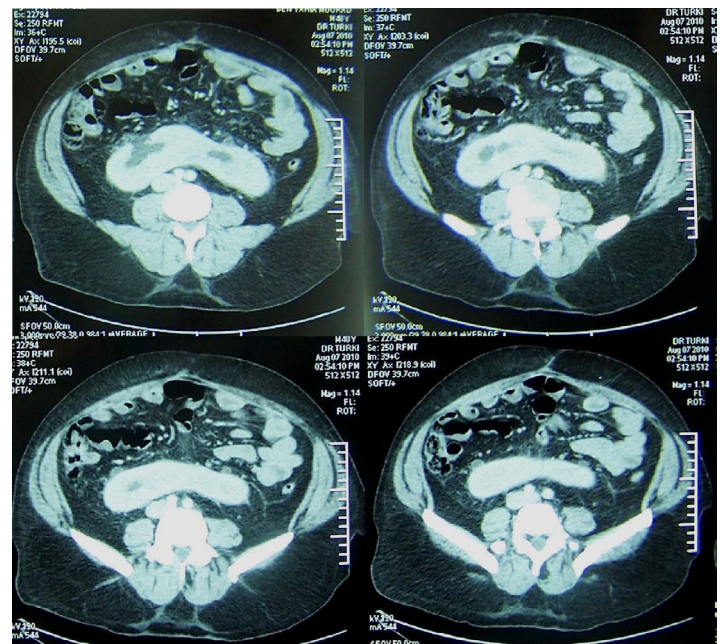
An abdominal CT scan of a horseshoe kidney with normal aspect parenchyma.
